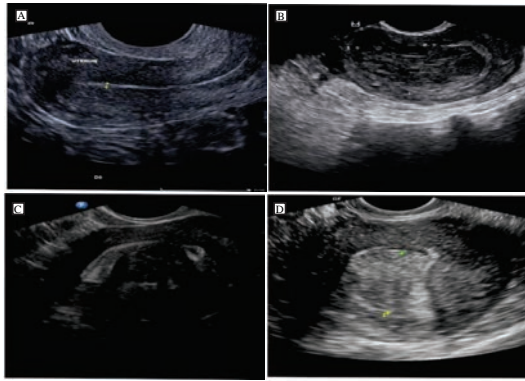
Transvaginal sonography images(1.Normal uterine cavity with triple layer endometrium, 2. Thickened endometrium, 3. Endometrial polyp, 4. Submucosal fibroid)
